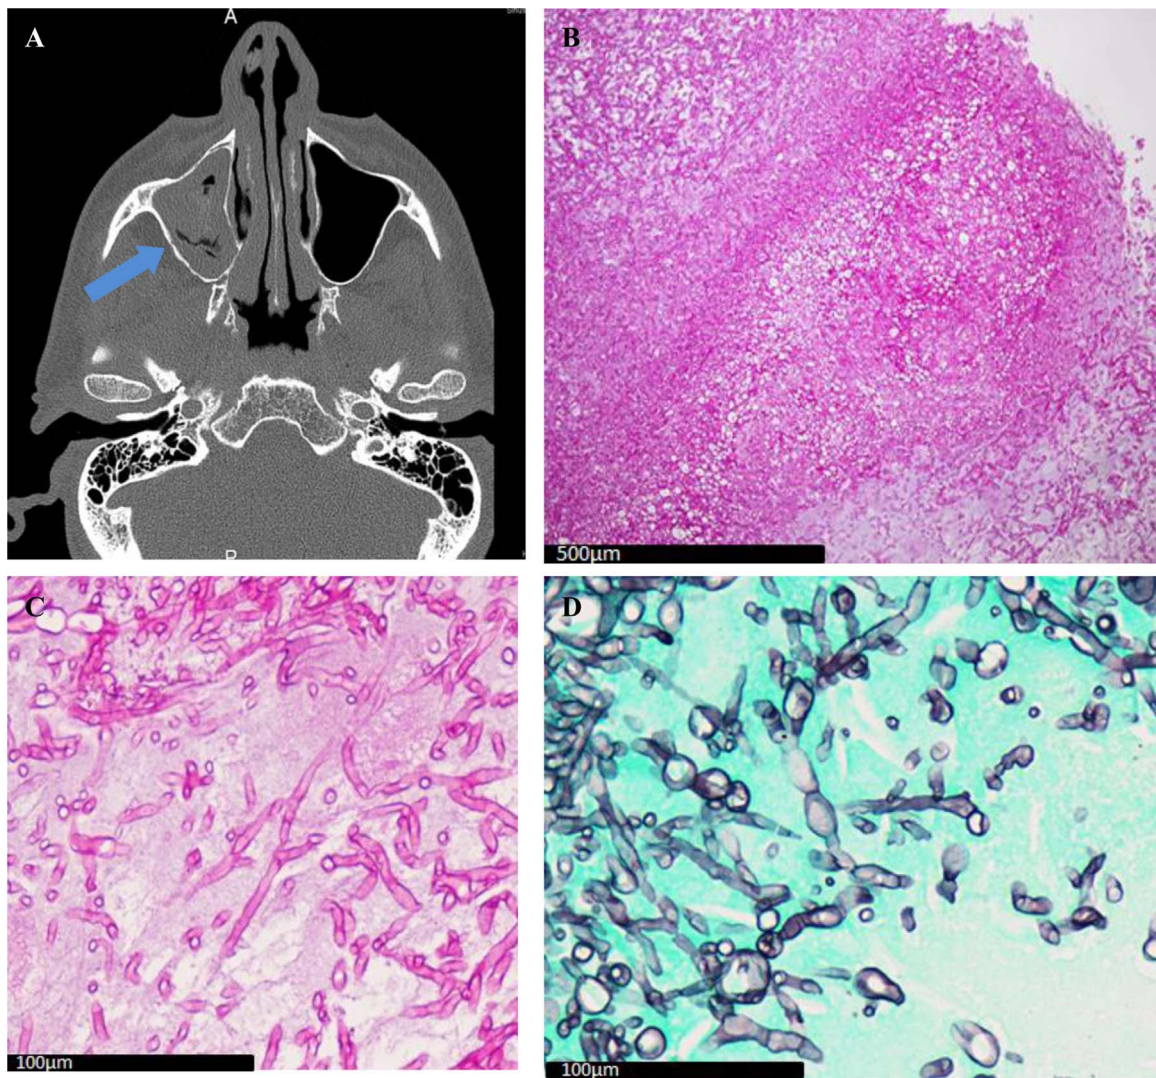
A: Sinus CT axial section: Filling of left maxillary sinus (blue arrow); B: Sinus biopsy (PAS  $\times 10$ ): *Aspergillus* fungus ball; C: Sinus biopsy (PAS  $\times 60$ ): *Aspergillus* hyphae; D: Sinus biopsy (Gomori Grocott  $\times 60$ ): *Aspergillus* hyphae.
